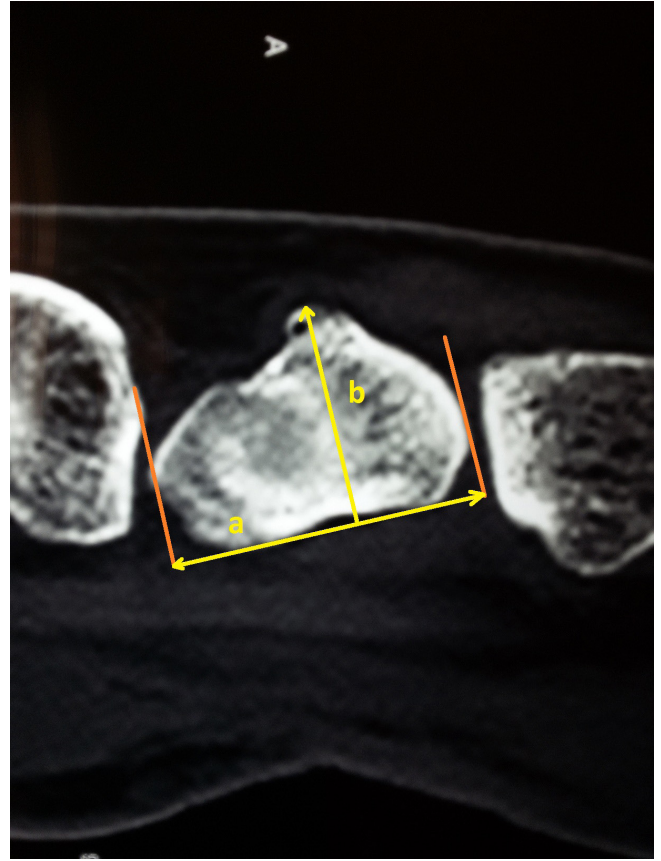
Measurement of the height-to-length ratio on CT scan.
